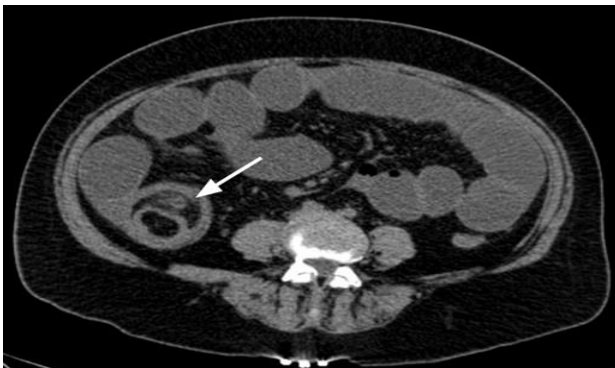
Axial CT of abdomen axial section with evidence of target sign at level of distal ileum, local edema, ovoid image inside intussuscepted loops, with no evidence of free fluid/ perforation.
